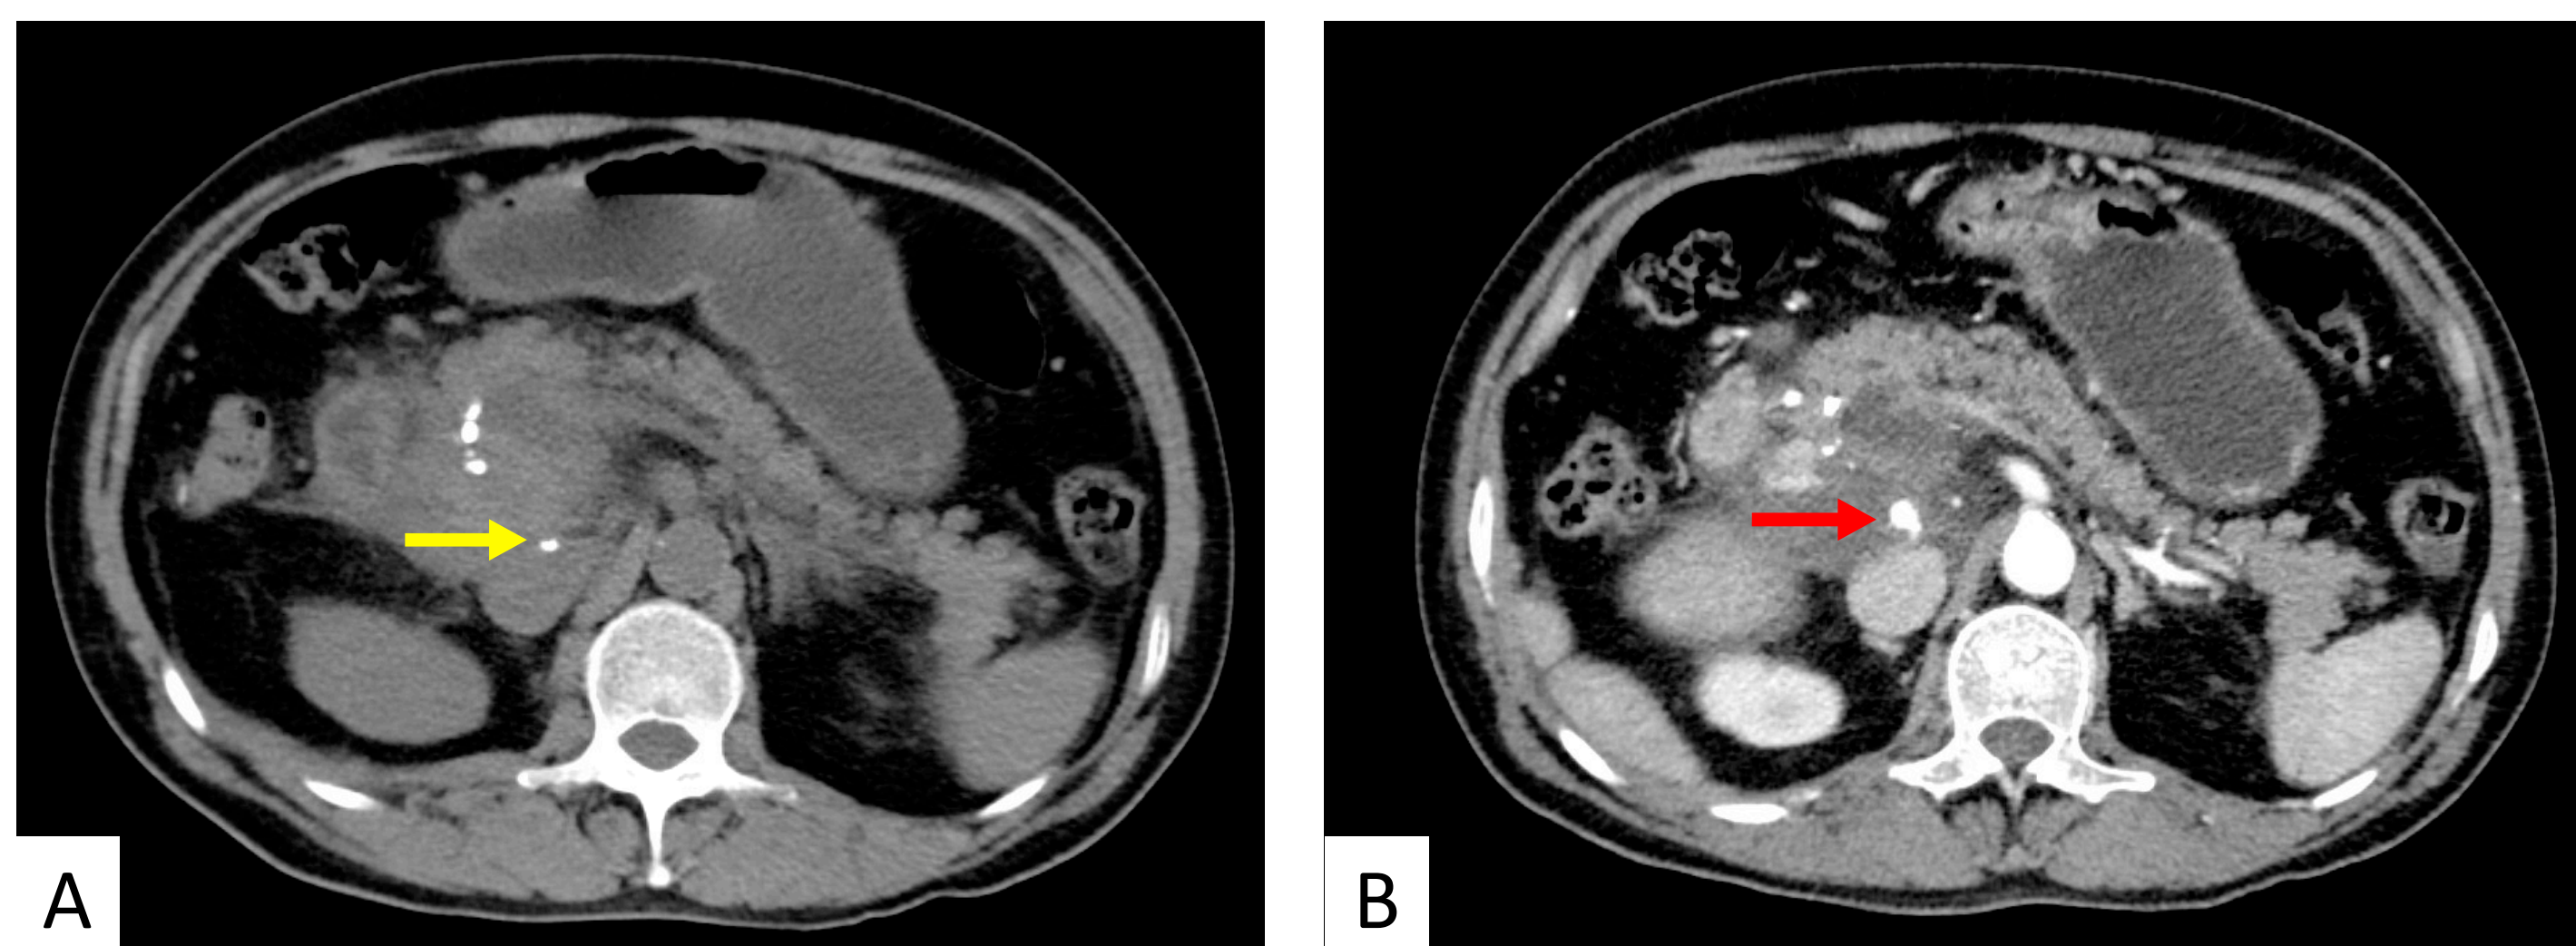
Pre-contrast (A) and arterial phase (B) axial CT images of the abdomen demonstrate findings consistent with acute hemorrhagic pancreatitis with large peripancreatic collection. A 1 cm area of arterial hyperenhancement in the posterior superior aspect of the collection is consistent with pseudoaneurysm (red arrow). Note calcification adjacent to the PSA on pre-contrast image (yellow arrow).
